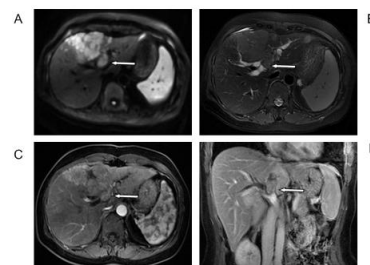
(case 2).Diffusion-weighted image (A), T2 weighted image (B), and enhanced magnetic resonance image (C, D) showing left liver lobe mass (black arrow), with intrahepatic bile duct invasion (white arrow).
